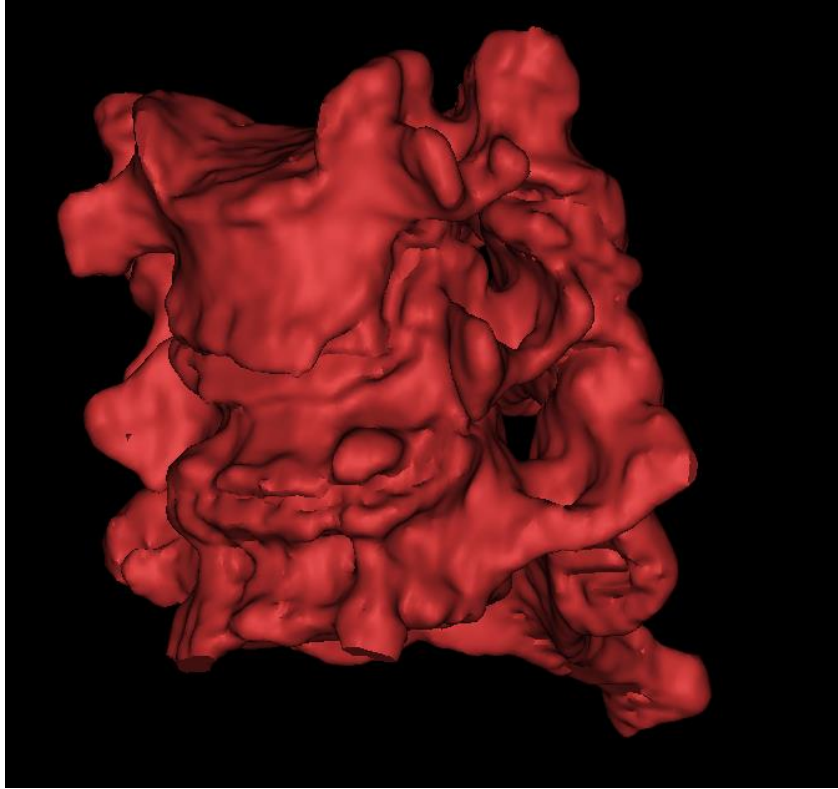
3D model into CT images perspective*
